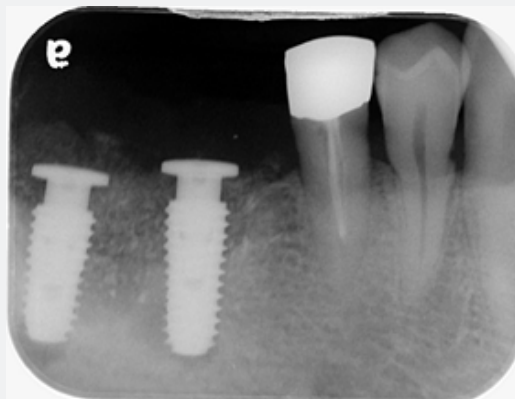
Periapical radiogram indicated peri-implantitis on the right mandibular 1st and 2nd molar areas.
